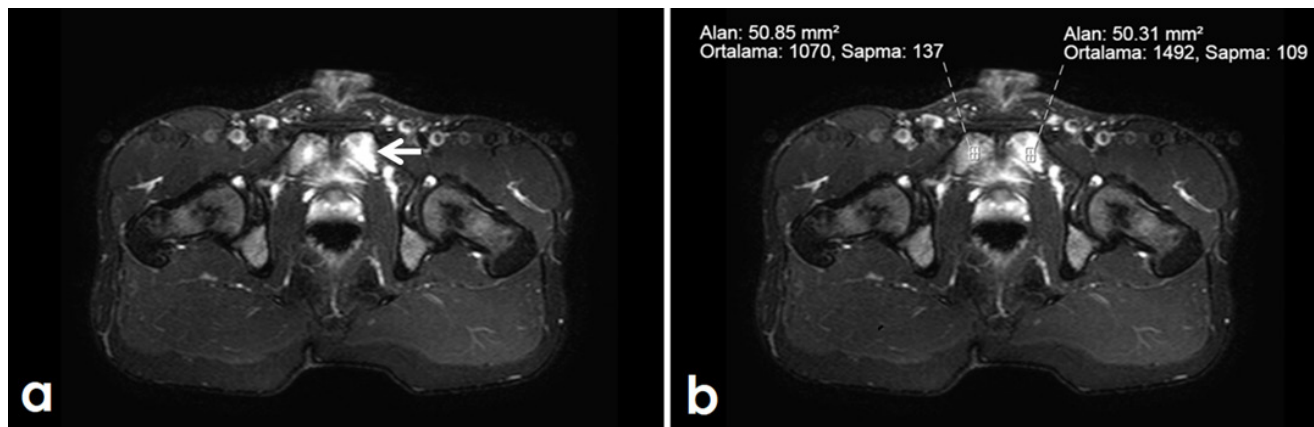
(a) Coronal MRI section of an 18-year-old professional footballer (patient 10) shows the left pubic bone having more hyperintense BME (arrow) compared to the right.
